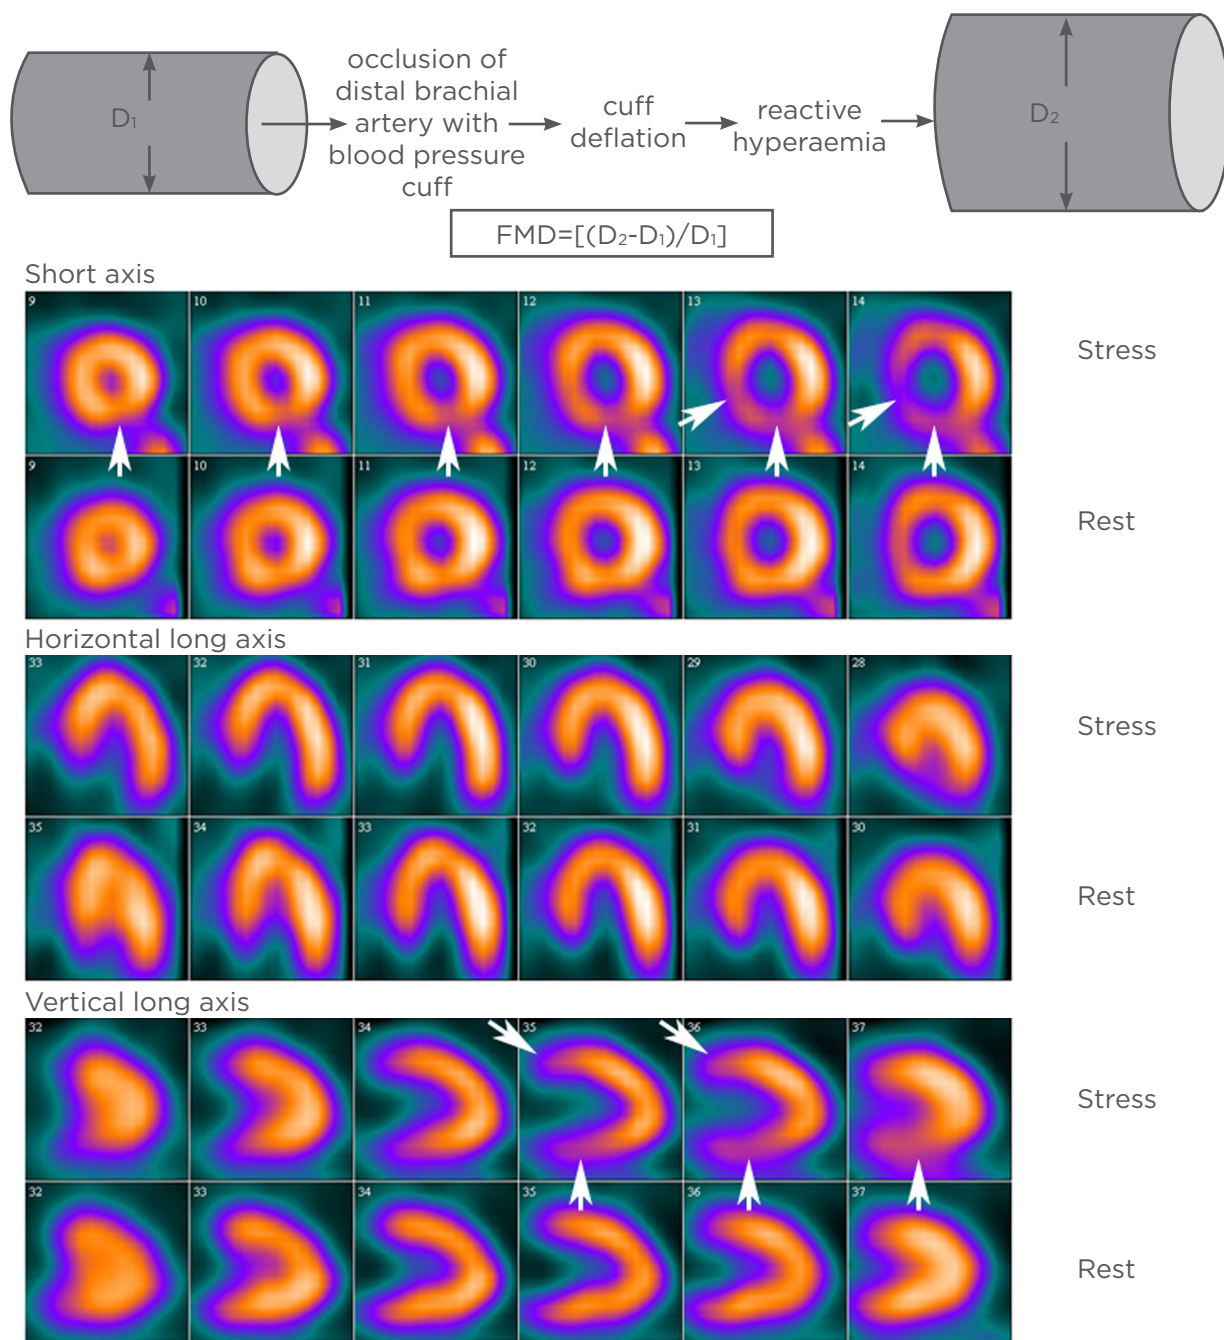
Assessment of flow mediated dilatation (top panel) and myocardial perfusion using gated single photon emission computed tomography at rest and after adenosine stress (bottom panel).
